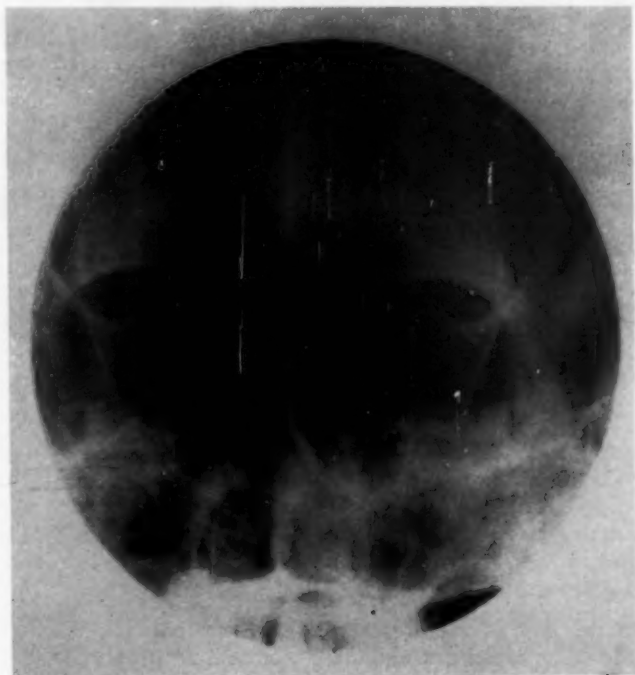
X-ray of paranasal sinuses ten years postoperatively, showing residual defect in ethmoid area.
